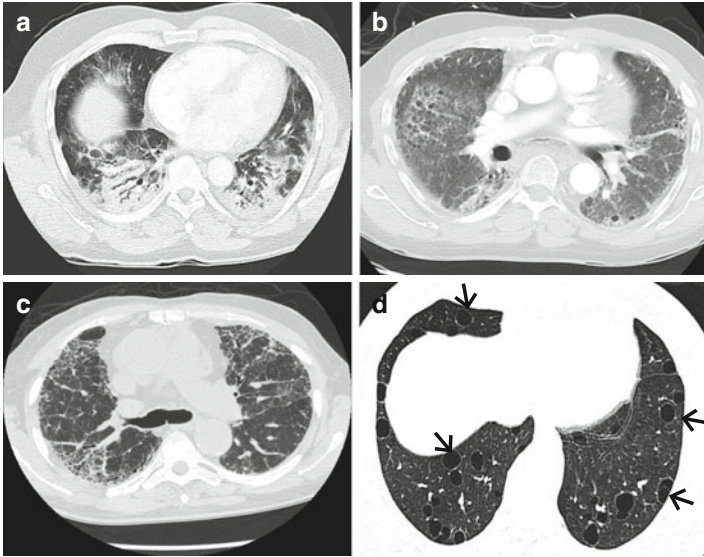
High resolution computed tomographic images demonstrating the heterogeneous radiographic appearance of connective tissue disease-associated interstitial lung disease. (a) Organizing pneumonia (rheumatoid arthritis), (b) fibrotic non-specific interstitial pneumonia (mixed connective tissue disease), (c) usual interstitial pneumonia (systemic lupus erythematosus), and (d) lymphocytic interstitial pneumonia (Sjögren's) with characteristic cystic changes as indicated by the arrows
